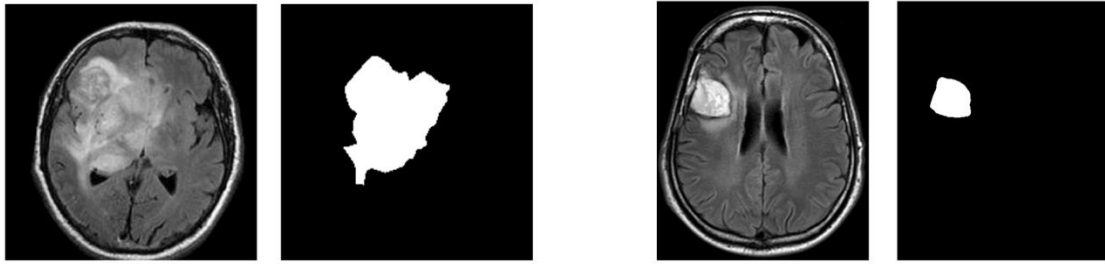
Left: An MRI with difficulty in creating the mask. Right: An MRI image that was easy to generate the mask for.
